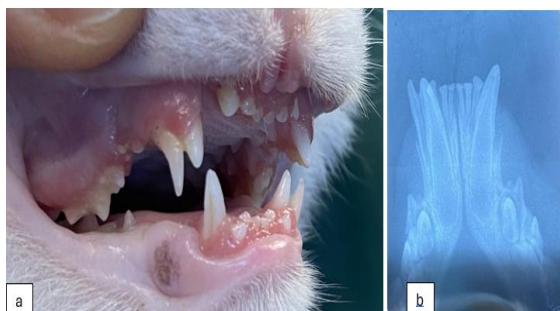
Persistent deciduous tooth case (a) and radiographic image (b)
